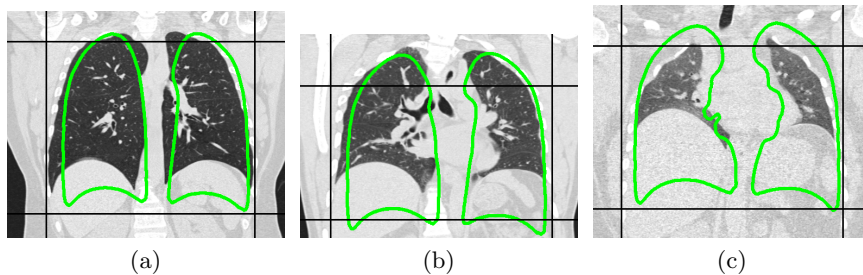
TLC images showing the rib-cage bounding box along with the associated initial ASM for three different cases: a) Correct ribs, b) Incorrect ribs, c) Correct ribs but a different CT scanning protocol. Note: scale here is computed isotropically based only on  $x$  and  $y$  extent of rib-cage [8].
